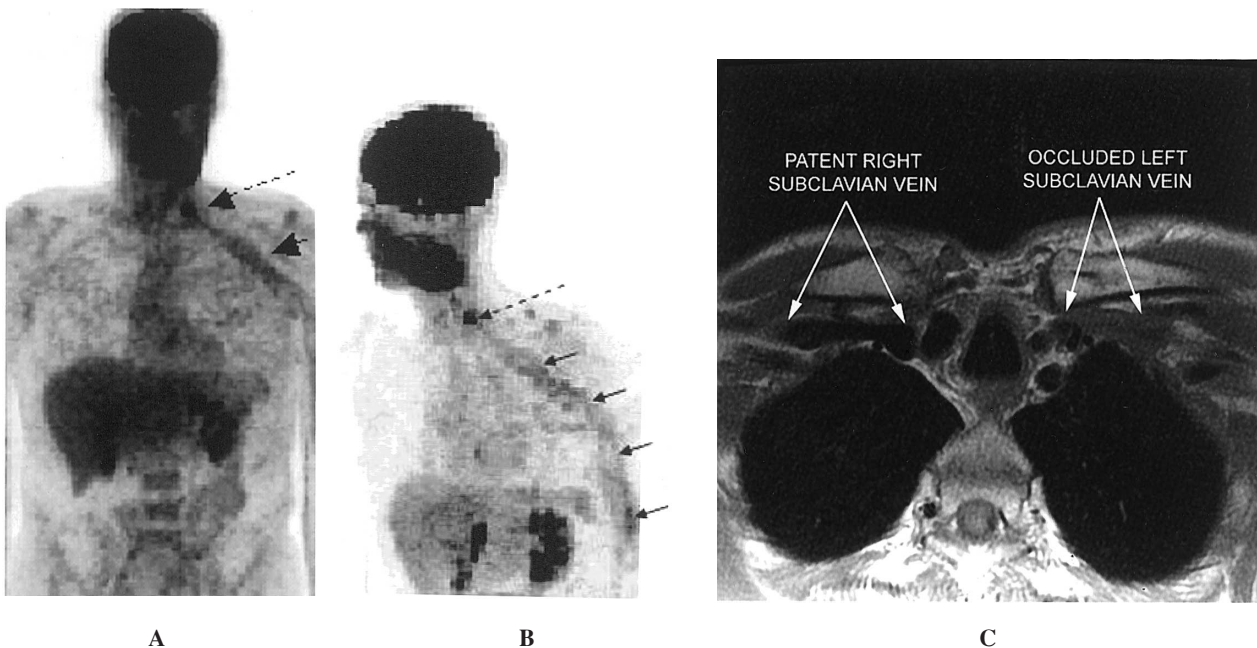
PET anterior (A) and LAO (B) views showing the trajectory of the aseptic venous thrombosis from left internal jugular vein, left subclavian, axillary vein and basilica vein with reactive left axillary lymphadenopathy in the. Note intense FDG activity in brain and bilateral upper renal collective systems. (C) Transverse T1-weighted MRI image through the subclavian vessels. The normal, patent right subclavian vein shows the normal, dark, low signal flow void expected for patent vessels using this MR technique. In contrast, the abnormal left subclavian vein is filled with intermediate signal (grey) intensity material that is consistent with clot.
